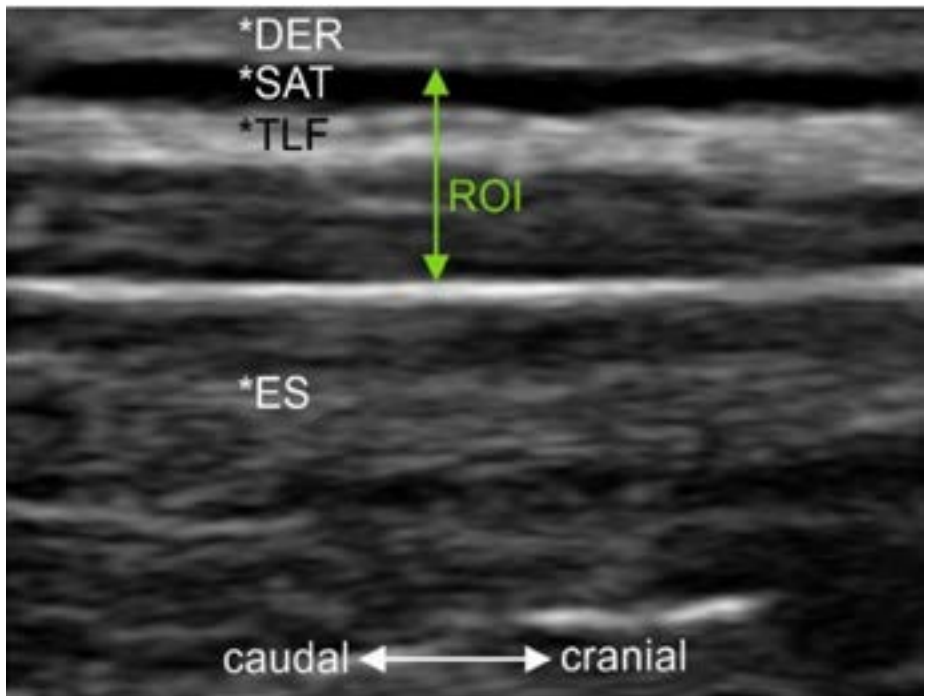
Sample ultrasound image section of thoracolumbar complex: *DER indicates dermis, *SAT indicates subcutaneous adipose tissue, *TLF indicates thoracolumbar fascia, *ES indicates erector spinae muscle, and ROI is the region of interest. [Permission to publish images allowed under Creative Commons Attribution (CC BY) license from Brandl et al. (2023).]
